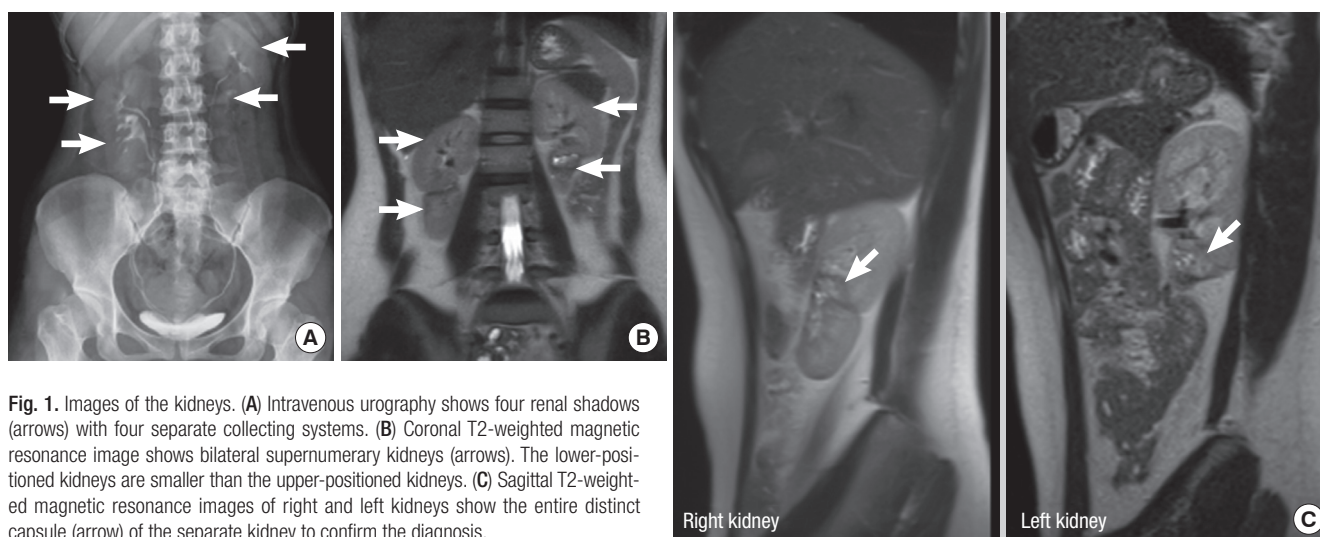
Images of the kidneys. (A) Intravenous urography shows four renal shadows (arrows) with four separate collecting systems. (B) Coronal T2-weighted magnetic resonance image shows bilateral supernumerary kidneys (arrows). The lower-positioned kidneys are smaller than the upper-positioned kidneys. (C) Sagittal T2-weighted magnetic resonance images of right and left kidneys show the entire distinct capsule (arrow) of the separate kidney to confirm the diagnosis.
